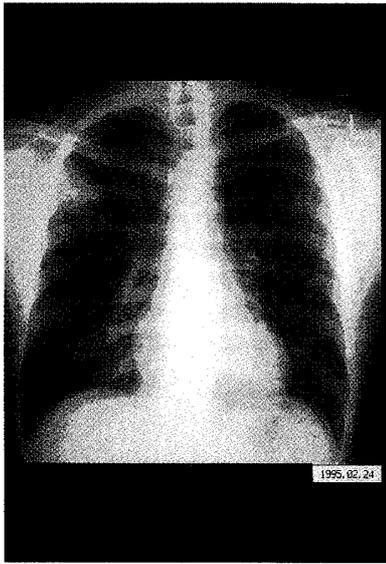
Chest radiograph on initial visit revealing a mass shadow in the right upper lung
